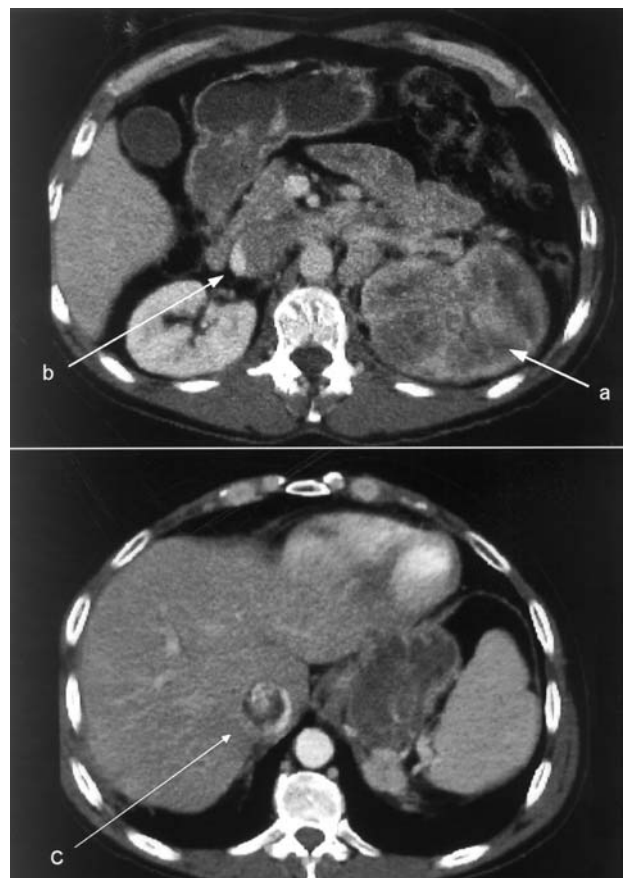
Computed tomography of the abdomen revealing a renal cell carcinoma of the left kidney (a) with tumour thrombus invading the inferior vena cava (IVC; b).
